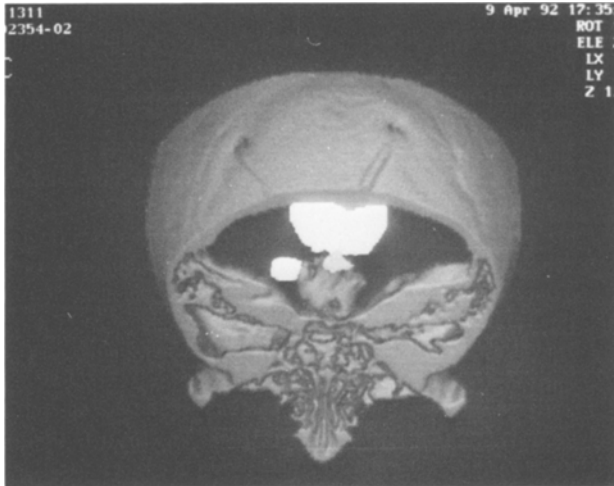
3D CT reconstruction of a multicystic case
